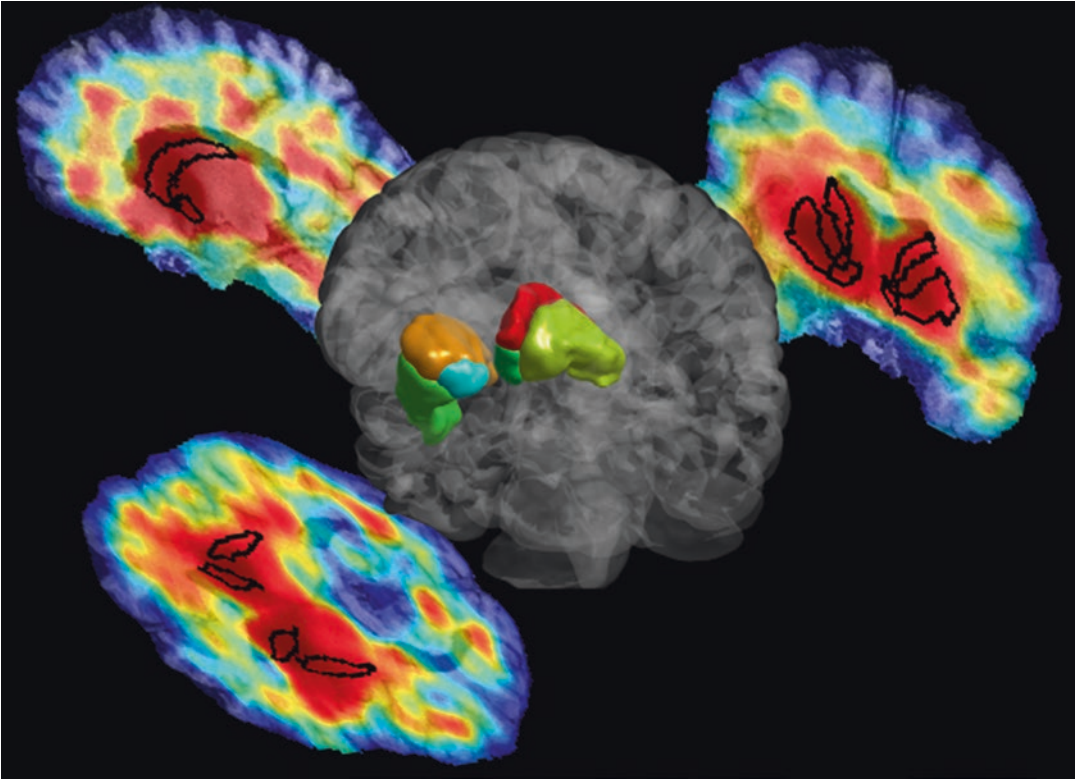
3D volume rendering of six segmentations (caudate, putamen and VS; both right and left) for a typical study, as well as trans axial, coronal, and sagittal slices through the DAT SPECT image with superimposed segmentations. (Used under the Creative commons license
